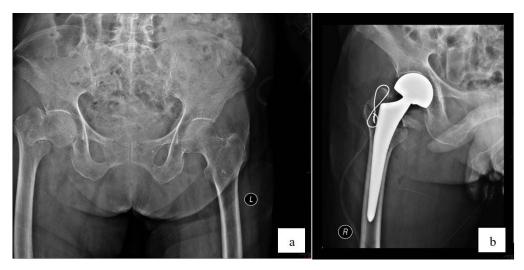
Hip Fracture. (a) X-ray of right fracture pertrochanter hip. (b) X-ray after bipolar arthroplasty and sanar wire augmentation.
